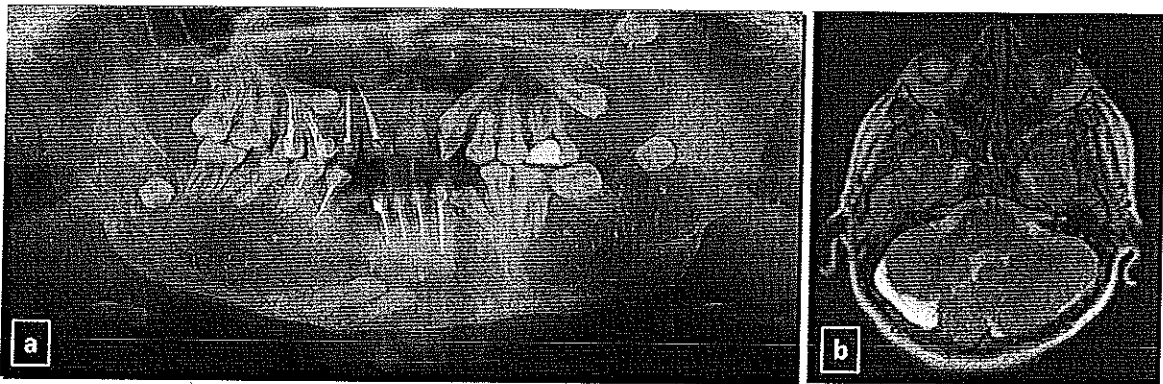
(a) Multiple odontogenic keratocysts on a panoramic radiograph. (b) Vermian dysgenesis.
